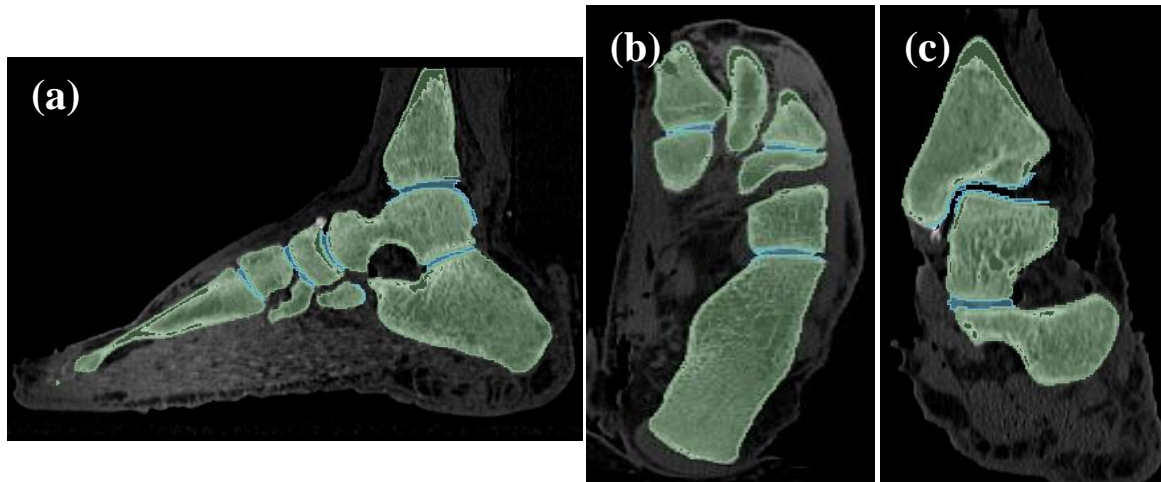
The CT scan images in three different views with bones (green) with cartilage segments (blue); (a) sagittal view, (b) axial view, and (c) coronal view.
